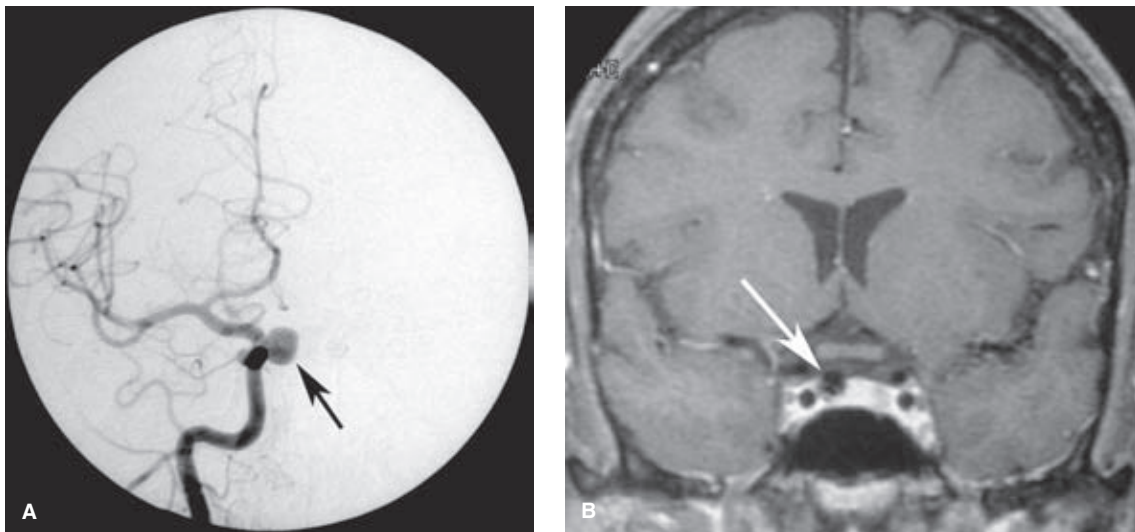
(A–B) Intrasellar aneurysm from the cavernous internal carotid artery. A PA angiographic view (A) of a right internal carotid artery injection in a middle-aged female with multiple aneurysms. A medially directed aneurysm from the cavernous internal carotid artery is present (arrow). Aneurysms in this location are thought to correspond with the hypophyseal or capsular branches. The intrasellar location was confirmed on a coronal T1-weighted, gadolinium-enhanced MRI study (B). Although this particular aneurysm was asymptomatic, endovascular treatment was recommended. Intrasellar aneurysms that rupture can leak into the subarachnoid space, causing significantly greater morbidity than rupture of cavernous aneurysms in other positions.
